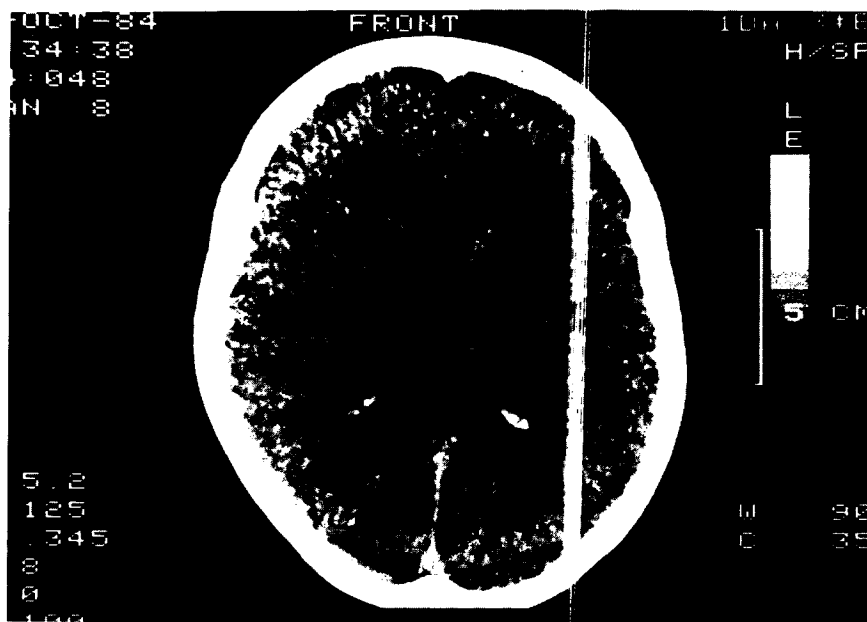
CT scan depicting a hypodense area in the right insula consistent with infarction.
